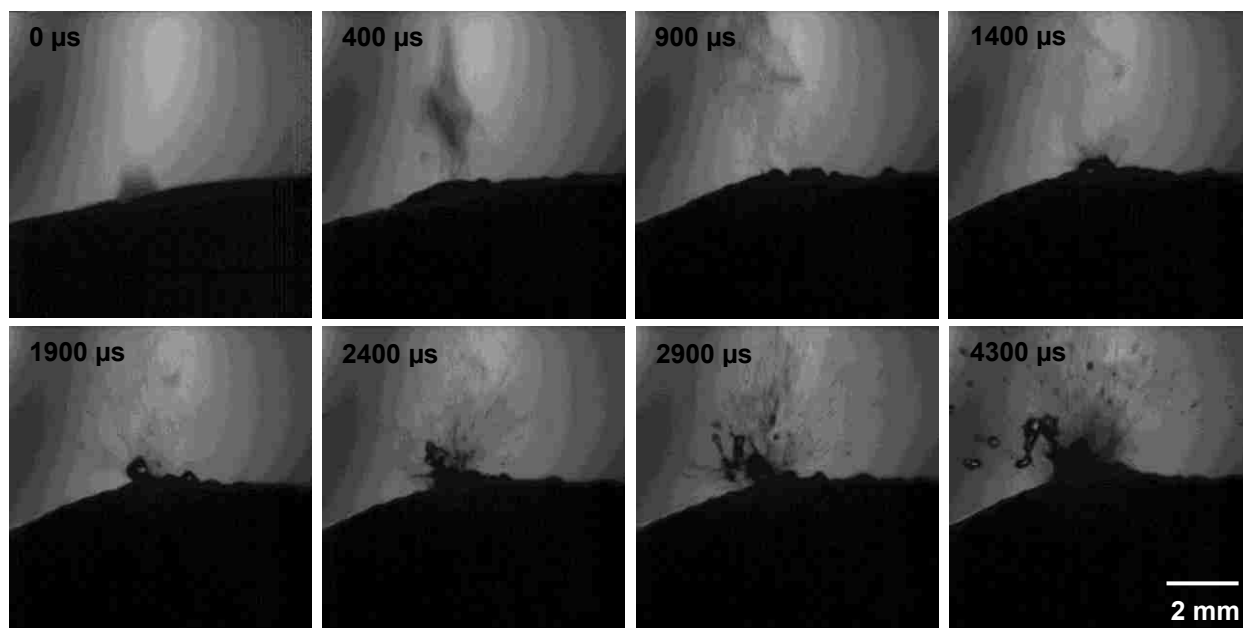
High speed video frames of atomization of the intact *in vivo* liver capsule when wetted with soapy water. The first frame shows that the initial fine spray is emitted as the ultrasound wave encounters the liver surface (70 μ s prior to the frame). The second and third frame shows the mound forming in the tissue surface with atomization continues. In the fourth frame (1400 μ s), we see the soapy water fountain beginning to form. As the fountain forms, it atomizes very dramatically. In the 6th and 8th frames, if we backtrack along the direction of many of the jets, we can see that they appear to be originating at or near the liver capsule surface. We expect this is what caused the liver capsule to be breached. 2 MHz HIFU operating at the maximum *in situ* intensity of 14,000 W/cm² (p_+ = 53 MPa, p_- = 12.5 MPa) was pulsed with 10-ms pulses at 1 Hz.
